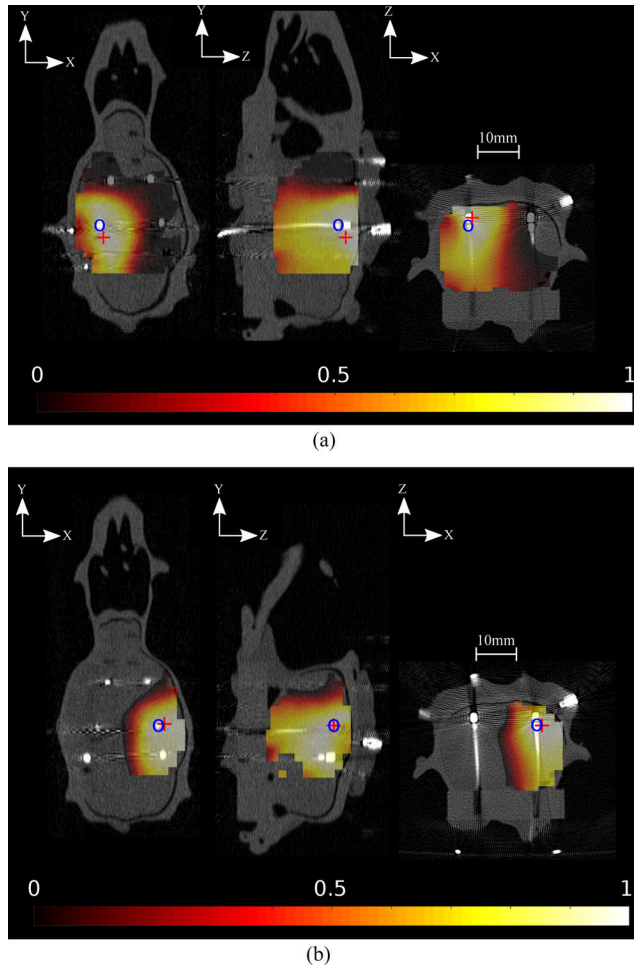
Normalized source distributions estimated for d3 (a) and d4 (b) excitations corresponding to the worst and the best accuracy respectively. The normalized estimated source power (hot colormap) was interpolated onto the CT scan (gray scale), reference dipole positions are marked with a circle, and global maxima of source distributions are marked with a cross. Power values were normalized with respect to their maximum value in each instance d3 and d4 excitation, thus the source distribution is presented by a unitless quantity here.
